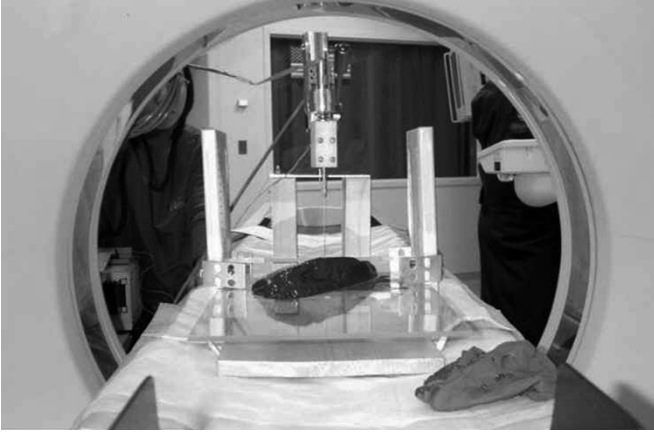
Experimental setup for data collection under CT fluoro imaging. A translational stage controls the motion of the needle. The liver is suspended between two clear acrylic plates, and small holes in the plates allow the needle to pass through.
